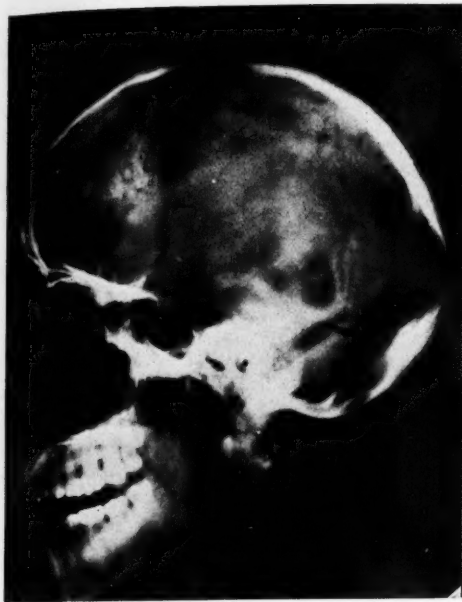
X-ray No. 31,373. Man, age 47. *Complaint:* Right-sided convulsions, duration 4 years. *P. E. shows* weakness of right side, partial aphasia, and bilateral choked disc. *Operation:* Left trans-frontal. Partial removal of cystic tumor from left temporal lobe. *Pathological report:* Glioma. *X-ray shows* a large irregular mass of calcification in the left temporal region, probably calcification in a glioma.
